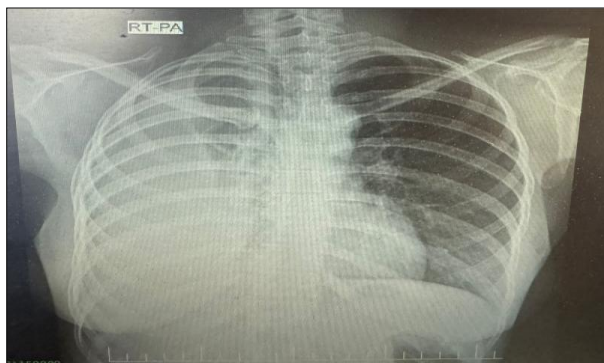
Chest X-ray showing massive right sided pleural effusion.
